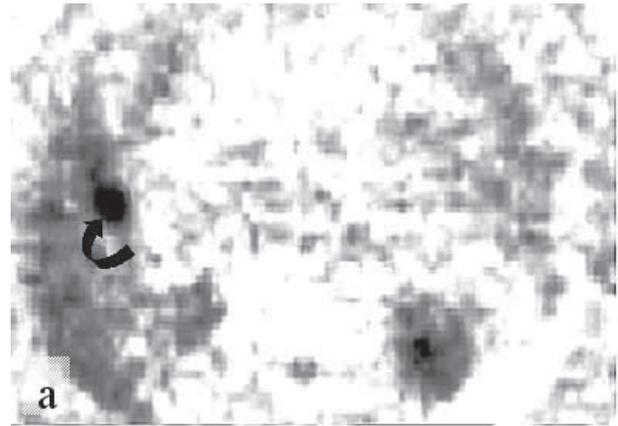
Axial (a) and coronal (b) FDG-PET images confirm abnormal metabolic activity with a very high standardized uptake value of 7.3 in the nodule (*curved arrows*).
